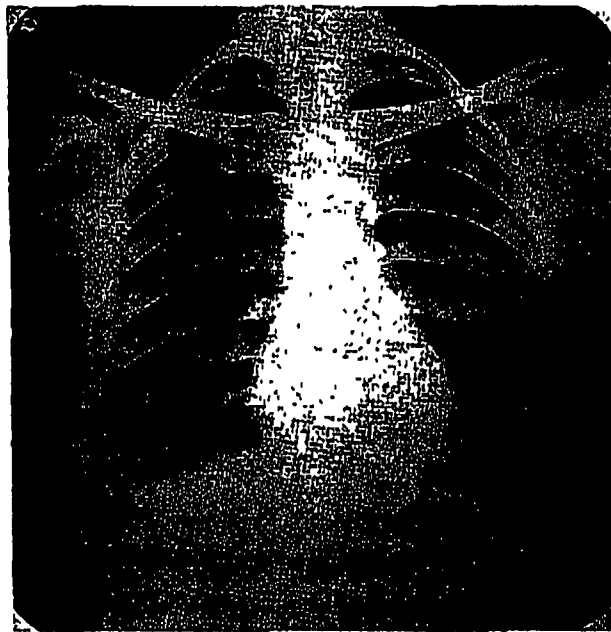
Normal chest radiograph. Female, aged 24 years; married.
